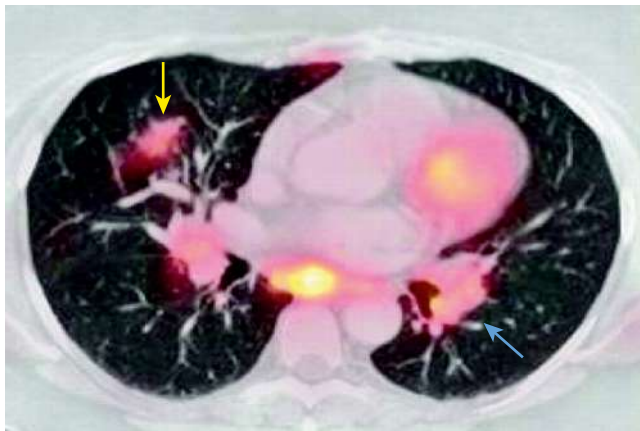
Confluent parenchymal lung nodules and mediastinal and bilateral hilar lymphadenopathy with increased FDG uptake in a female with biopsy-proven sarcoidosis. PET/CT shows confluent parenchymal lung nodules (yellow arrow) and mediastinal and bilateral hilar lymphadenopathy (blue arrow). These abnormalities show increased FDG uptake on fused PET/CT. (Modified from Prabhakar HB, Rabinowitz CB, Gibbons FK, et al. Imaging features of sarcoidosis on MDCT, FDG PET, and PET/CT. *AJR Am J Roentgenol.* 2008;190:S1–S6, Fig. 6, p. S4.)
